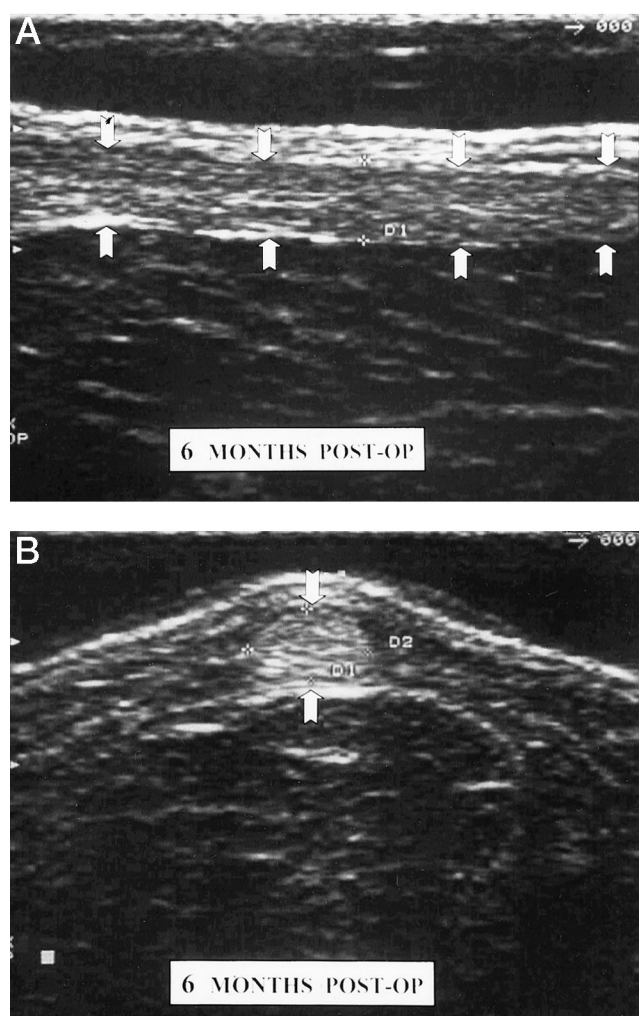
Longitudinal (A) and transverse (B) sonograms at 6 months after surgery. The area of the semitendinosus tendon is outlined by the arrows.
